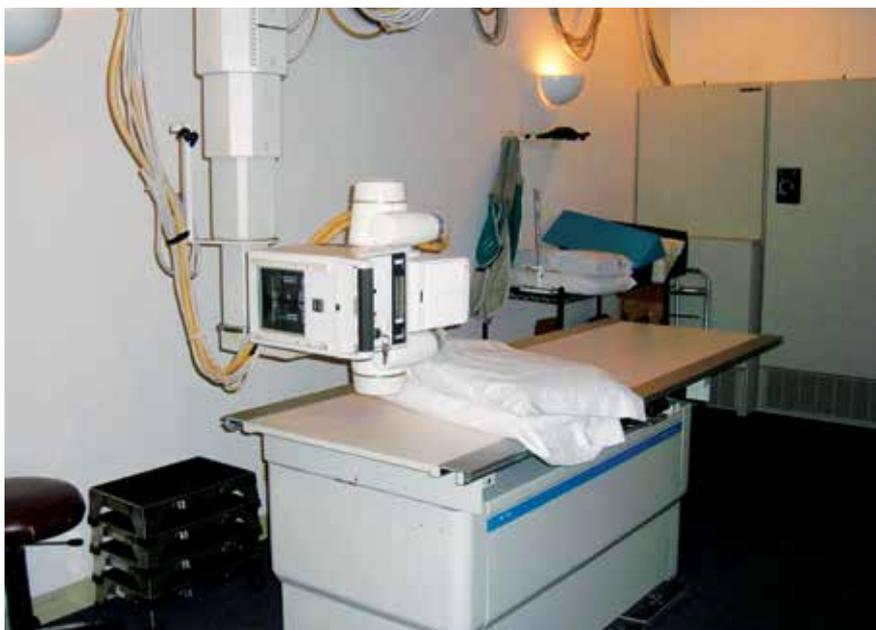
X-ray Generator
